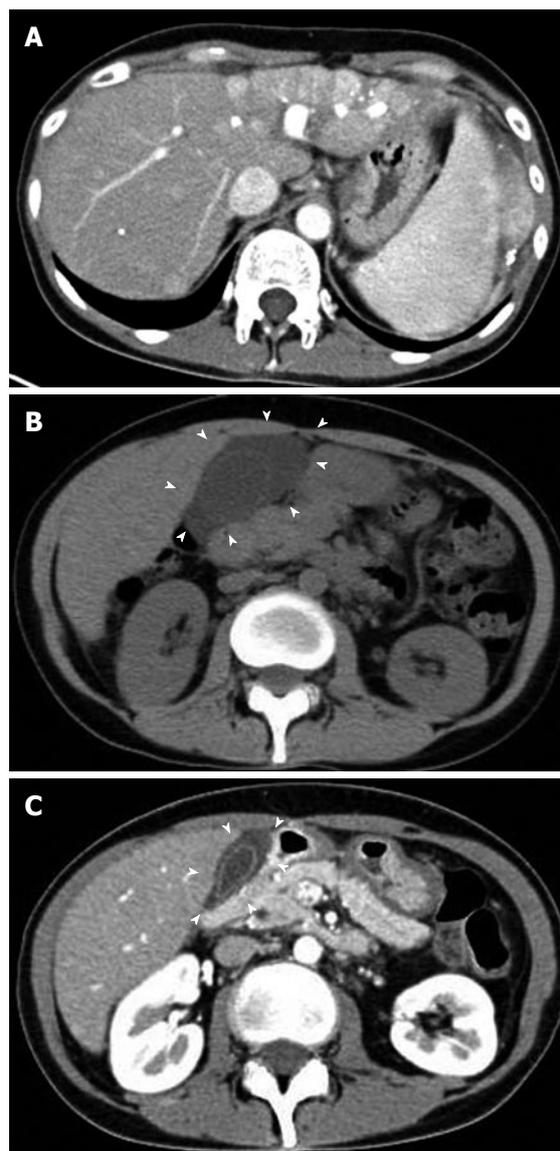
Abdominal computed tomography scan of the patient. A: Enhanced abdominal computed tomography (CT) scan showing the diffuse HCC which occupied whole left lobe and several new lesions within diameter 1 cm in right liver before the treatment with sorafenib. Triangle indicates the HCC lesion; B: Abdominal CT scan at the onset of acute cholecystitis during the treatment with sorafenib. The CT revealed the gallbladder swelling with exudate associated with severe inflammation without stones or debris (arrowheads); C: Follow-up abdominal CT scan at 5 d after treatment of acute cholecystitis. Gallbladder swelling was markedly improved with reduced ascites exudate (arrowheads).
